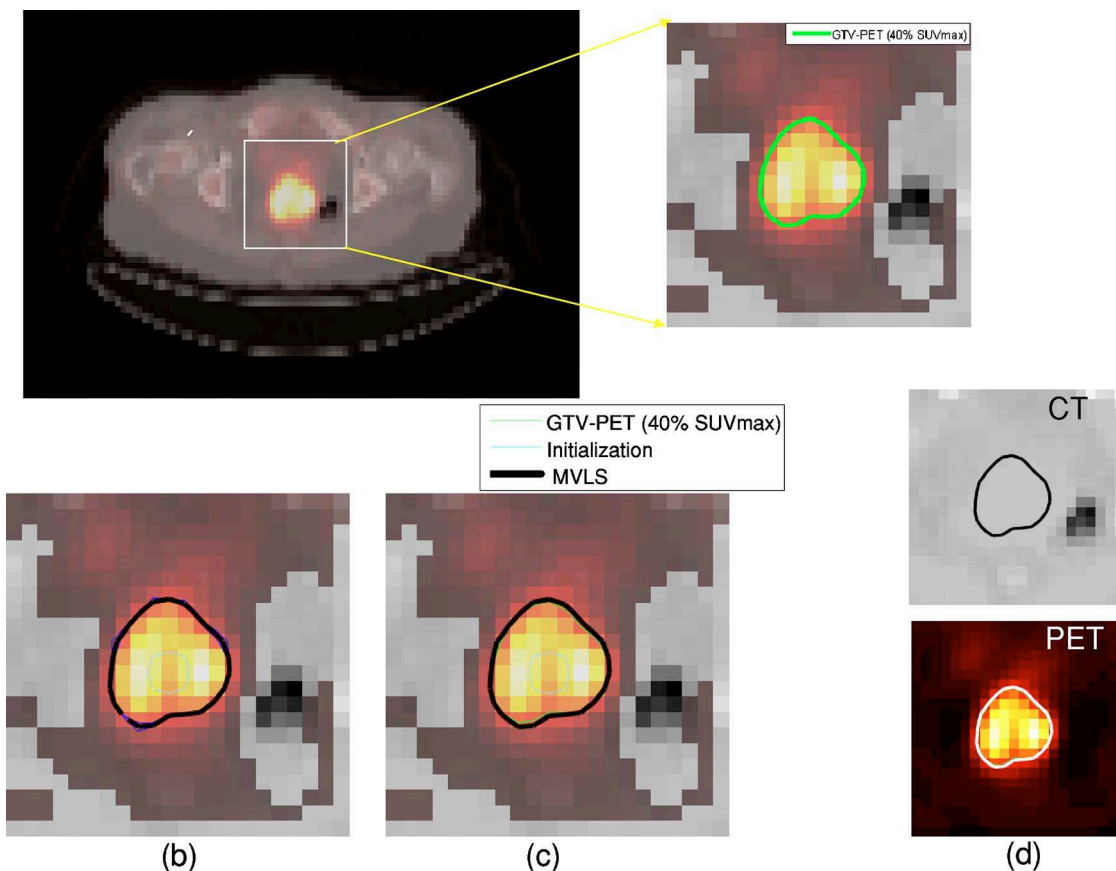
Analysis of cervix PET/CT. (a) Coregistered PET/CT after correction for small hardware misalignment with mutual information increasing from 1.22 to 1.23. The 40% maximum SUV contour (in green) is shown in the region-of-interest. (b) The MVLS algorithm is initialized with a circle (in white) of 15.9 mm diameter, curve evolution in steps of ten iterations (in blue), and the final estimated contour (in thick black). The algorithm converged in 30 iterations. This quick convergence is by part due to the deformed circular shape of the tumor and the PET sharp gradient. The PET/CT ratio weighting was selected as 1:1.25. (c) MVLS result is shown along with 40% SUV contour on the fused PET/CT. Note the high agreement as expected. (d) MVLS contour superimposed on CT (top) and PET (bottom). The PET/CT ratio weighting was selected as 1:1.25.
